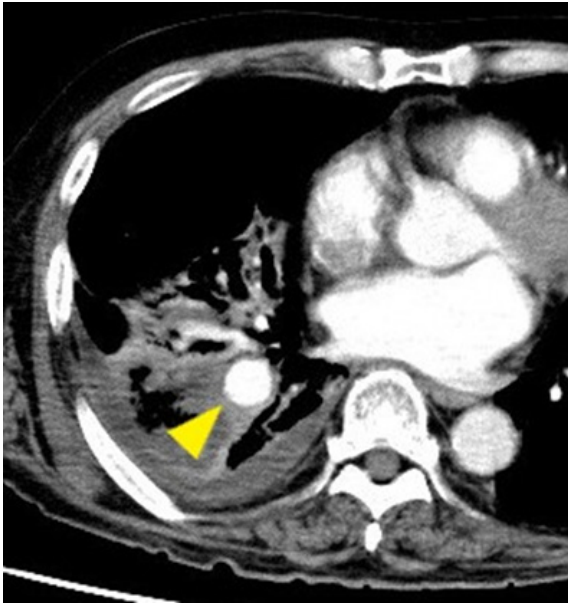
Contrast-enhanced computed tomography (CT) shows a 2-cm saccular aneurysm (arrowhead) in the right lower pulmonary artery.
